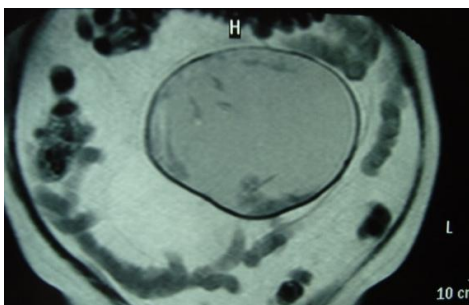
CT Scan-axial plane
